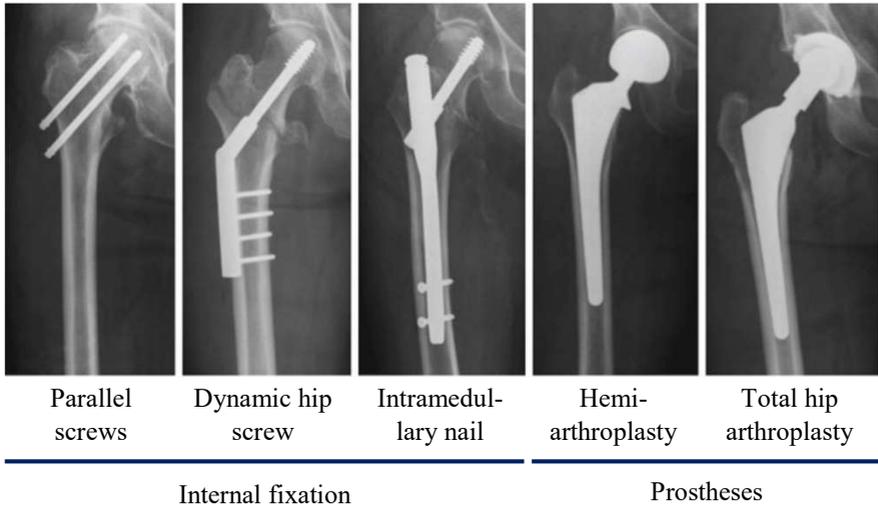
X-rays of implants used in the treatment of hip fractures [27].
